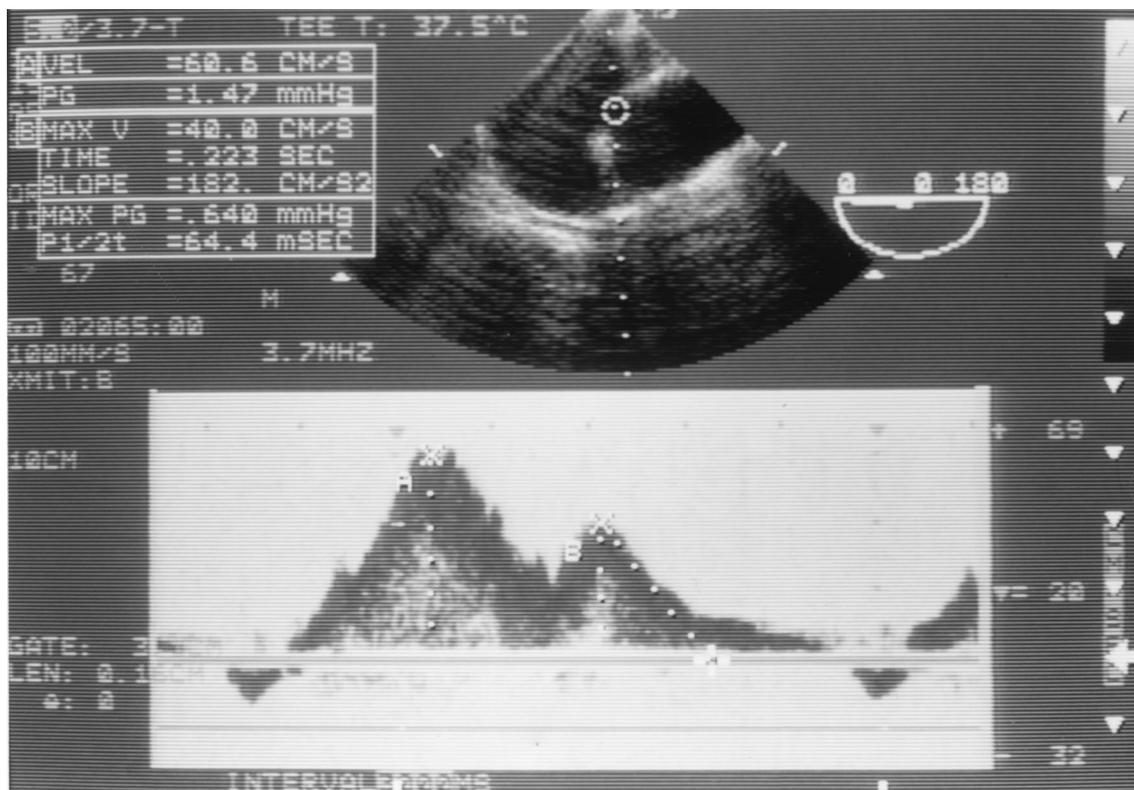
Transesophageal pulsed-wave Doppler showing a biphasic slope of deceleration of the diastolic wave (D) of pulmonary venous flow. The deceleration time of the D wave is measured as the time interval between peak velocity and the upper deceleration slope extrapolated to zero. The deceleration time in this case is 223 ms.
